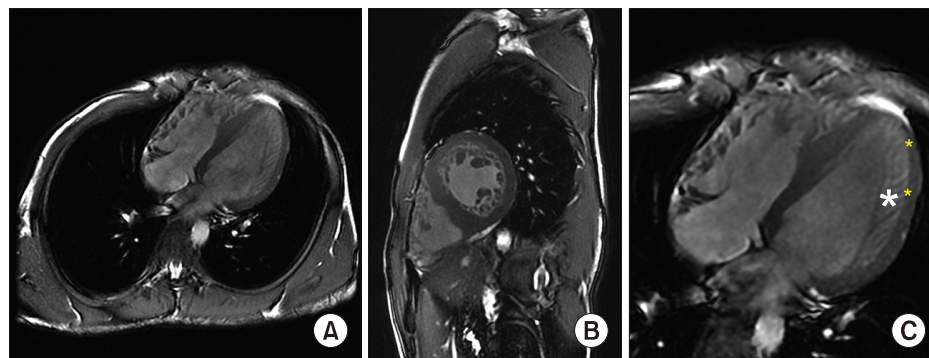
(A) Four-chamber view: Both right ventricle and left ventricle show hypertrabeculation in apex with typical 2-layer structure of the myocardium like in noncompaction cardiomyopathy. (B) Apical short-axis view demonstrating excessive apical to midventricular hypertrabeculation. (C) A four-chamber balanced steady-state free precession (bSSFP) cardiac magnetic resonance imaging shows a thinned myocardium at the apex and lateral walls (*yellow asterisks*) with prominent myocardial trabeculations (*asterisk*).
